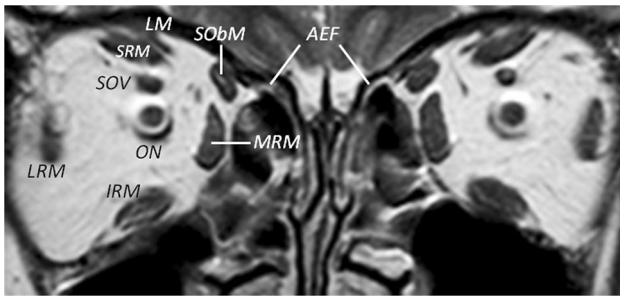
Coronal T2-weighted MR image at the level of the AEF demonstrating the SOV located between the SRM and the ON
